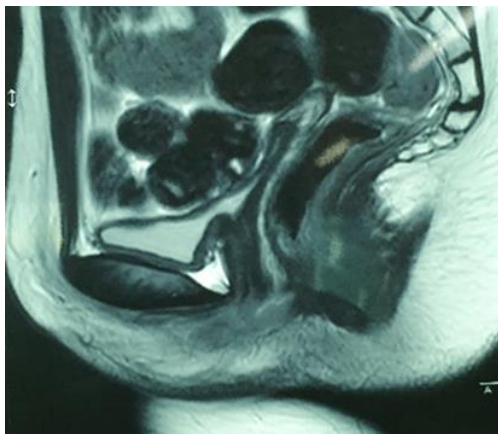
Sagittal plane view of MRI pelvis which show bilateral adnexa with no proper uterus formation
